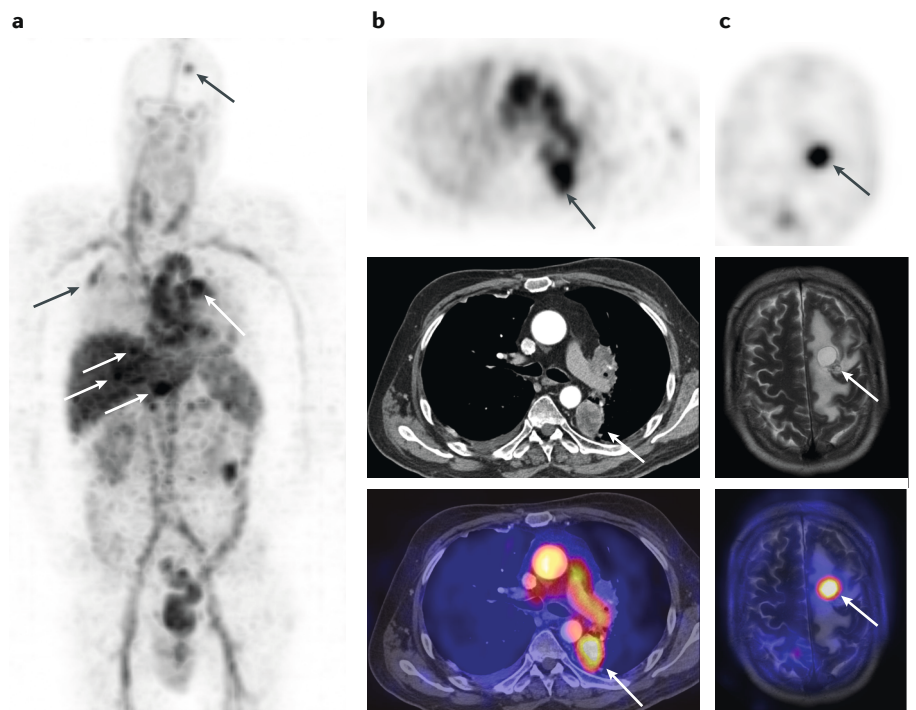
Example of multiplexed imaging with ⁸⁹Zr-bevacizumab-PET, CT, and MRI. a | ⁸⁹Zr-bevacizumab-PET maximum intensity projection image of a patient with metastatic renal cell carcinoma performed before first-line systemic treatment as part of a clinical trial to evaluate the feasibility of ⁸⁹Zr-bevacizumab-PET for VEGFA-based imaging biomarkers (NCT00831857). The image reveals metastases in the brain, lung, mediastinal lymph nodes, and liver (arrows). b | Transversal plane ⁸⁹Zr-bevacizumab-PET, CT and fusion images of the patient's chest providing anatomical imaging and ⁸⁹Zr-bevacizumab uptake data on the lung metastasis (arrow). c | Transversal plane ⁸⁹Zr-bevacizumab-PET, MRI, and fusion images of the patient's head provide analogous information on the brain metastasis (arrow).
